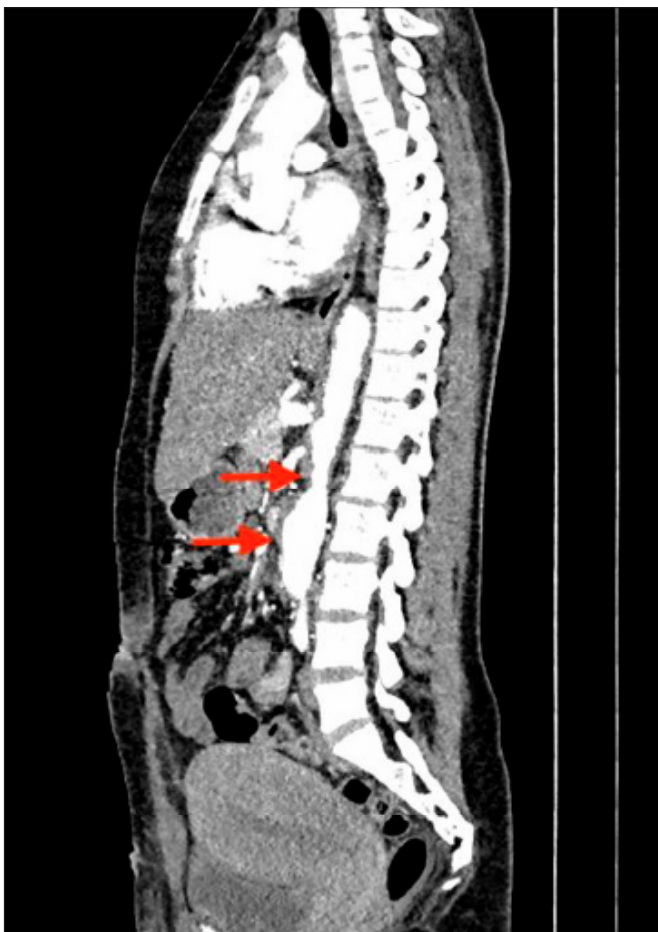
CT angiogram showing narrowing (top arrow) and dilatation (lower arrow) of the abdominal aorta
